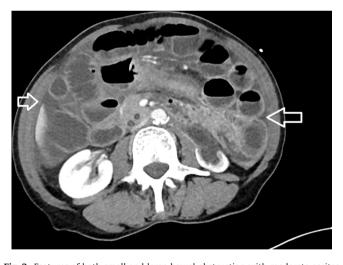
Features of both small and large bowel obstruction with moderate ascites can be seen on the computed tomography of the abdomen (left arrow). A transition point was seen in the proximal transverse colon without an obvious lesion (right arrow).
